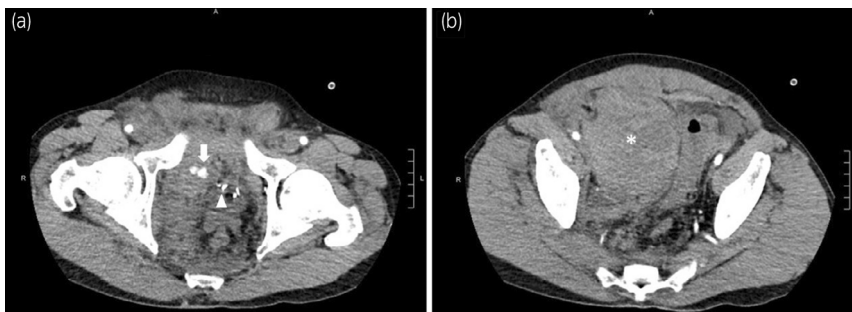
Urgent contrast CT scan of the patient after the developing hypotension. (a) The white arrowhead denotes the PUL tabs. The white arrow indicates the site of contrast extravasation, which is directly in line with the path of the PUL needle. (b) The white asterisk denotes the large retroperitoneal hematoma extending superiorly.
